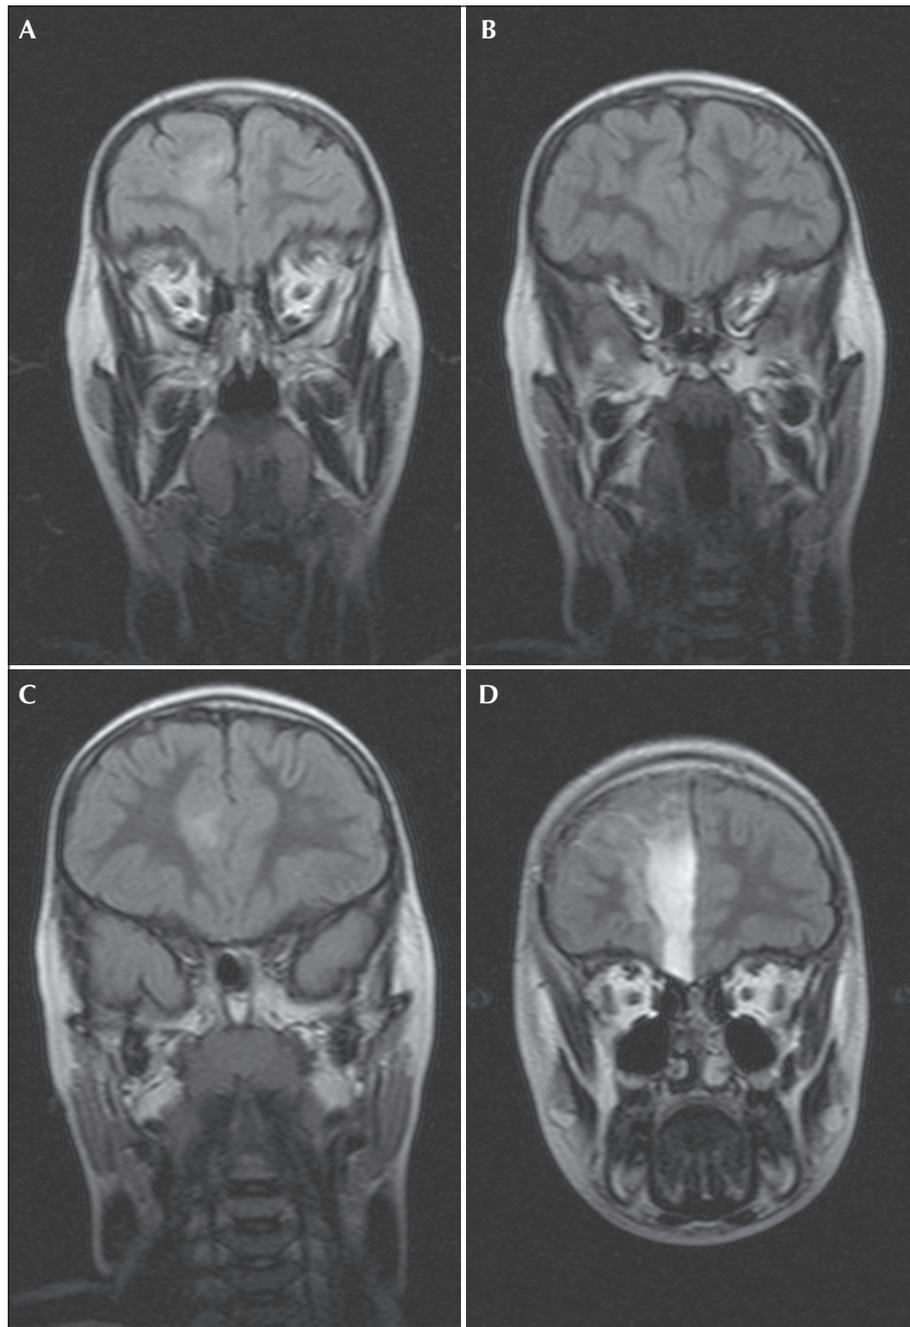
High-resolution MRI (coronal plane); FLAIR images.
